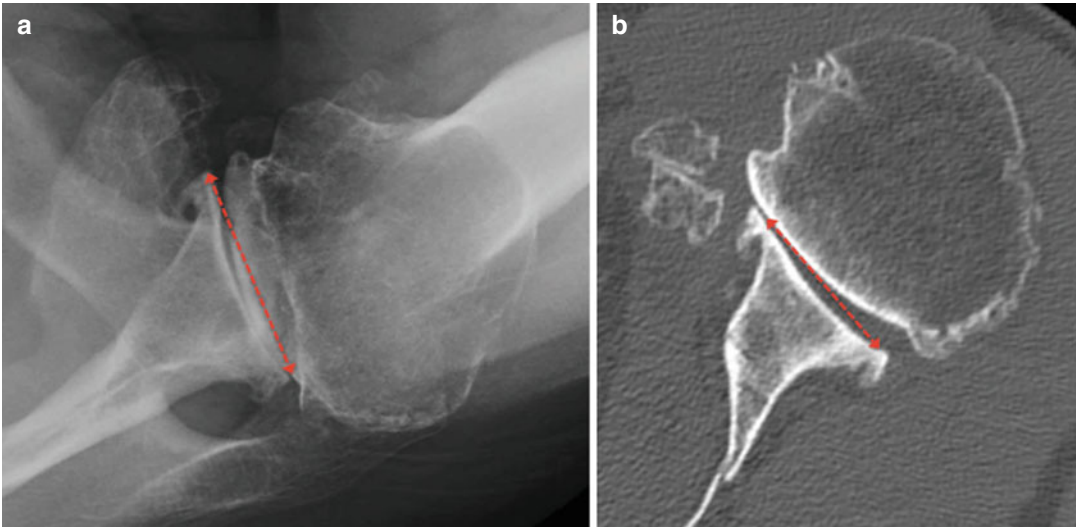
Glenoid width* – glenoid width can be measured from the most anterior and posterior points on the glenoid. This can be measured both on an AP radiograph (a) and CT coronal reconstruction image (b) (Note the osteophytes seen anteriorly and posteriorly which can overestimate the glenoid width)
